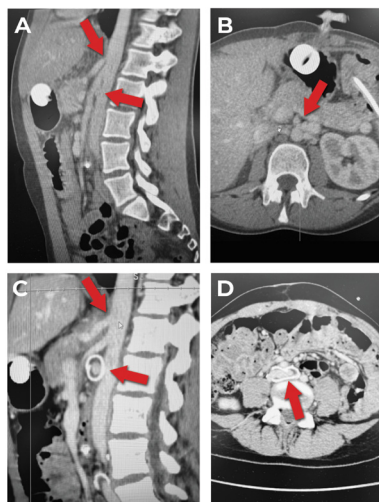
CT Abdomen and Pelvis with contrast. (A). Pretreatment: Visualization of celiac artery compression (top arrow), and reduced angle between aorta and SMA (bottom arrow). (B). Pretreatment: Compression of LRV between aorta and SMA (arrow). (C). Posttreatment: Resolution of celiac artery compression (top arrow). PTFE graft around LRV with increased angle between aorta and SMA (bottom arrow). (D). Posttreatment: PTFE graft around left iliac vein addressing MTS (arrow).
